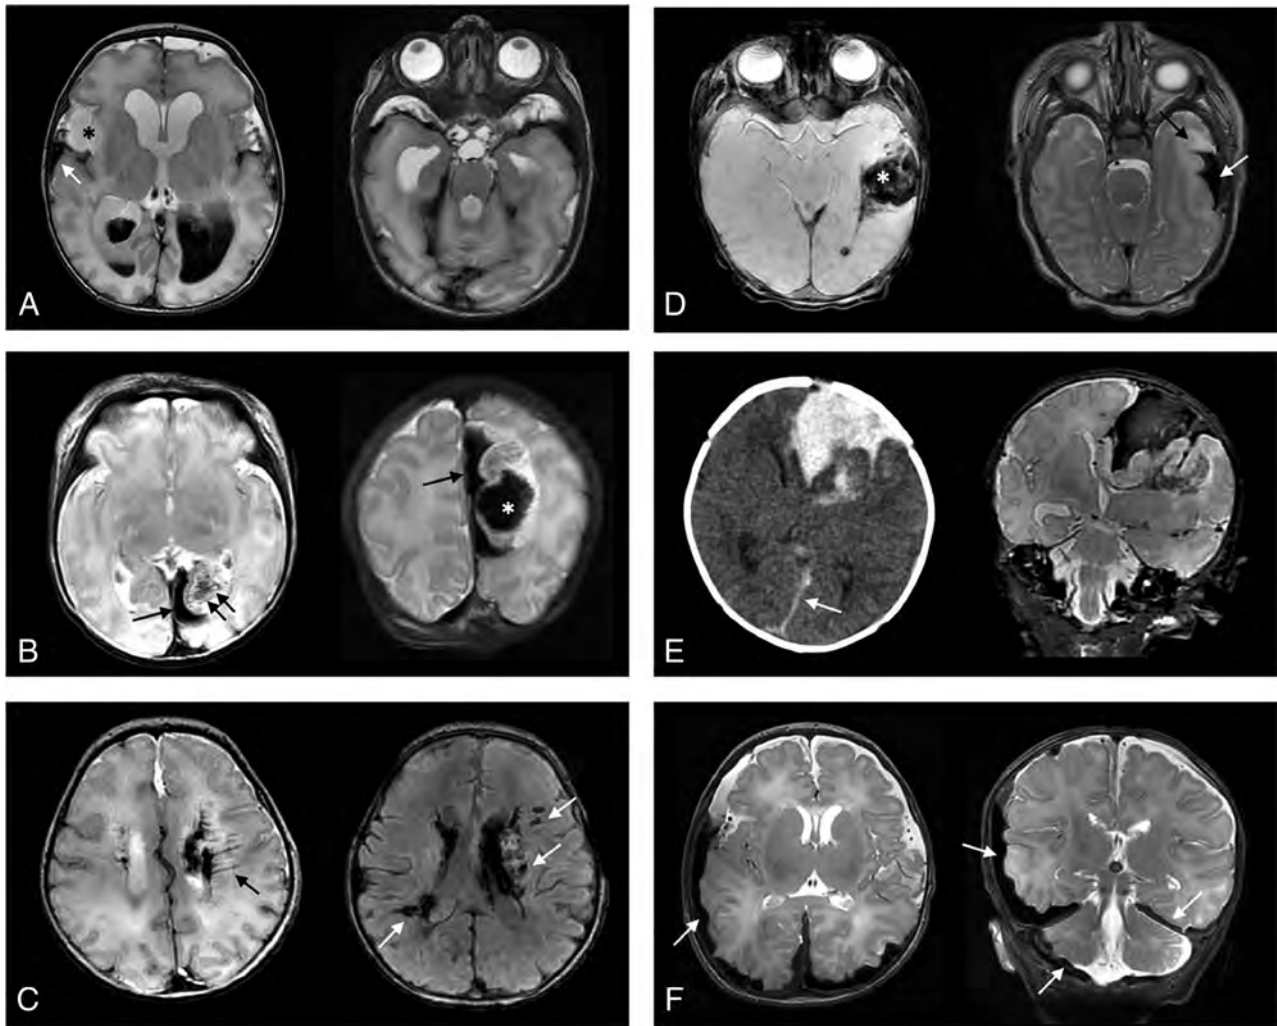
Examples of various anatomic distributions of intracranial hemorrhages in term or late-preterm neonates. *A*, IVH and associated ventriculomegaly are present. Tentorial subdural hemorrhage is also present, as well as hemorrhage overlying the bilateral temporal poles. Right temporal lobe swelling (*asterisk*) is present and associated with subpial hemorrhage (*arrow*). *B*, Left occipital subpial hemorrhage (*single arrow*) is present, as well as left parieto-occipital lobe parenchymal hemorrhage (*asterisk*). Linear low signal intensities (*double arrows*) suggest either venous congestion or thromboses. *C*, Intra- and periventricular hemorrhages are present. Linear intensities (*black arrow*) and nodular intensities (*white arrows* on T2* imaging) suggest a perimedullary vein congestion and/or thromboses. *D*, Subpial hemorrhage is seen (*white arrow*) with subjacent temporal lobe deformity and edema (*black arrow*). On T2* imaging, parenchymal hemorrhage is also seen (*asterisk*), as well as punctate intraventricular blood products. *E*, Combined left frontal subpial and parenchymal hemorrhages are shown on CT and MR imaging. Small falcine subdural hemorrhage is also shown (*arrow*). *F*, Bilateral cerebral convexity, posterior fossa, and tentorial subdural hemorrhages (*arrows*) are present in a neonate with hemophilia.
